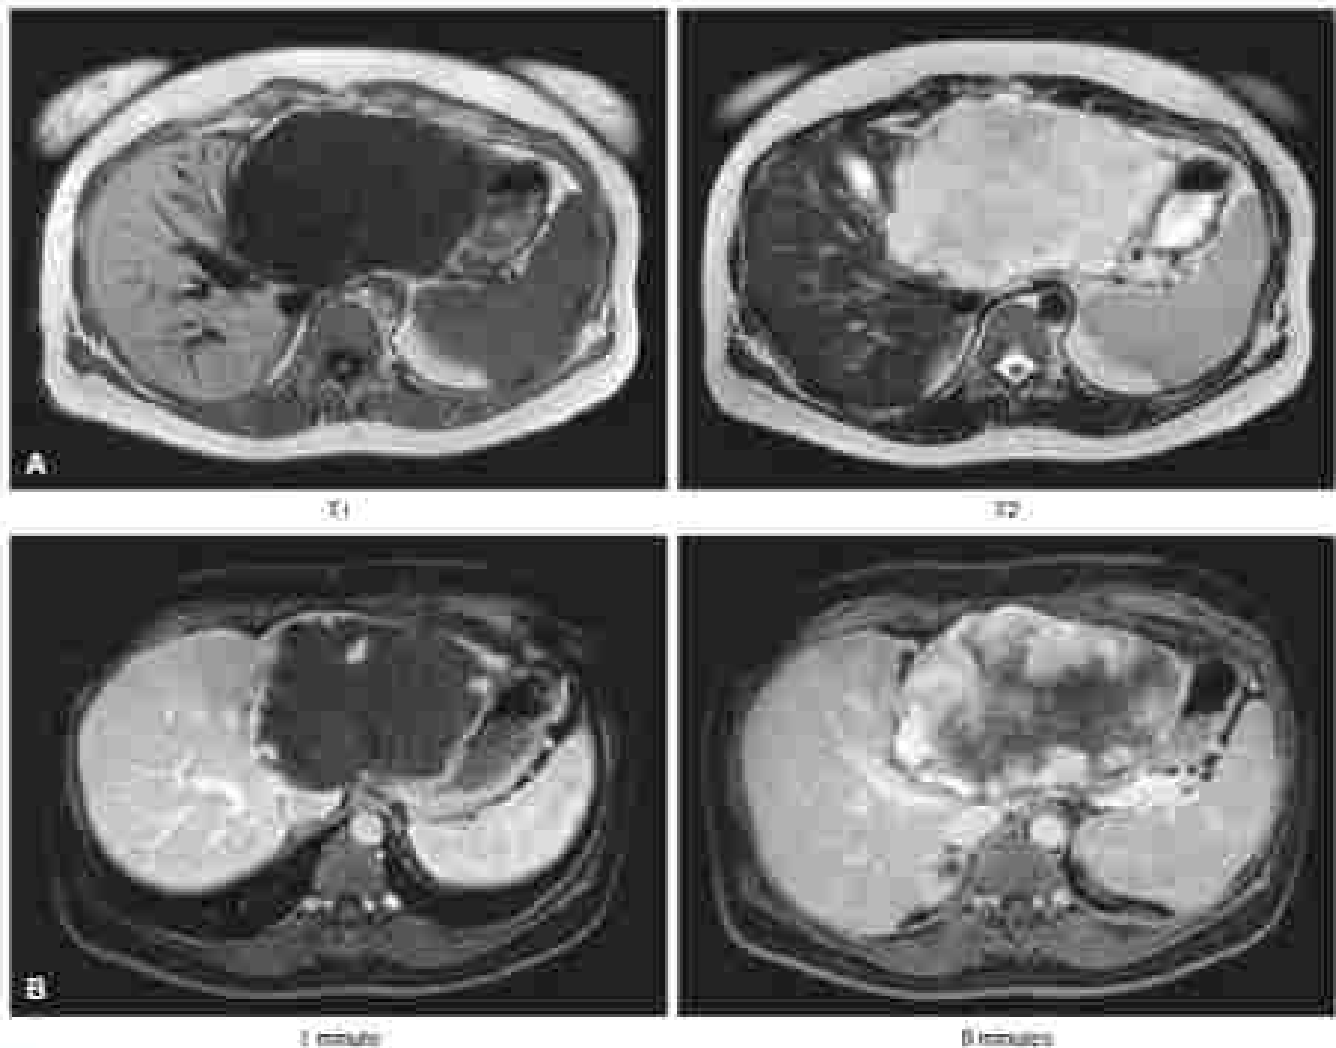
(A) Homogeneous signal hypointense on T1-weighted magnetic resonance imaging and hyperintense on T2-weighted images, as shown by this large left hepatic lobe mass in a 51-year-old woman. (B) Dynamic contrast-enhanced imaging demonstrating peripheral contrast enhancement over time, which is pathognomonic for hemangioma.
